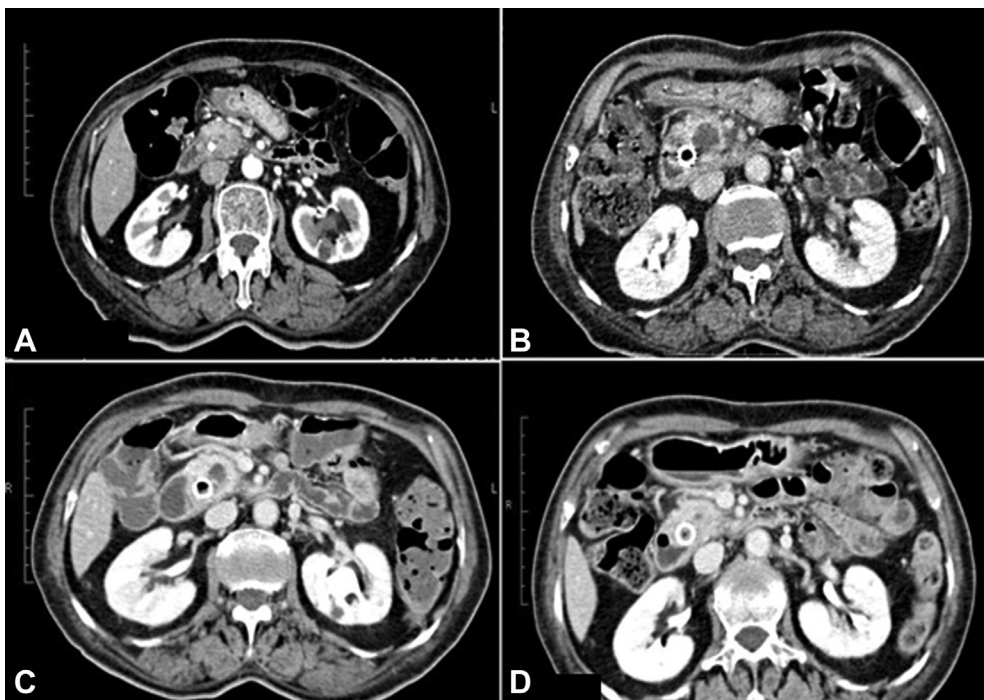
A, CT scan: pretreatment arterial phase showing a pancreatic head focal lesion. Delayed phase showing the coagulation area adjacent the biliary metal stent, with a well-demarcated rim of postcontrast enhancement at 24 hours (B), 7 days (C), and 30 days (D). Power setting, 3 W, 800 J, 270°.
